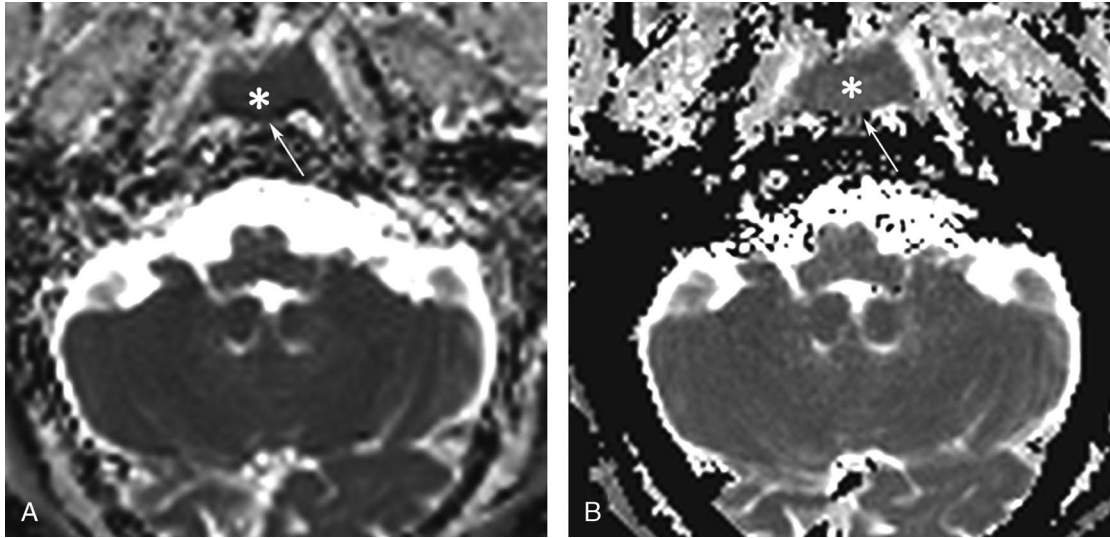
A 59-year-old male patient with neoplasm (white star) in the bilateral nasopharyngeal wall (white arrow). The ADC maps of RS-DWI (A) and SMS-RS-DWI (B) show focal low signal intensity in the corresponding region with similar ADC value.
